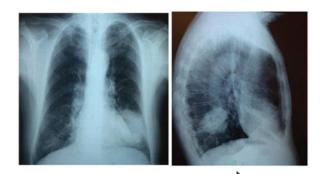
Chest X-ray showing basilar opacity of the left lung: (a) antero-posterior view and (b) lateral view.
